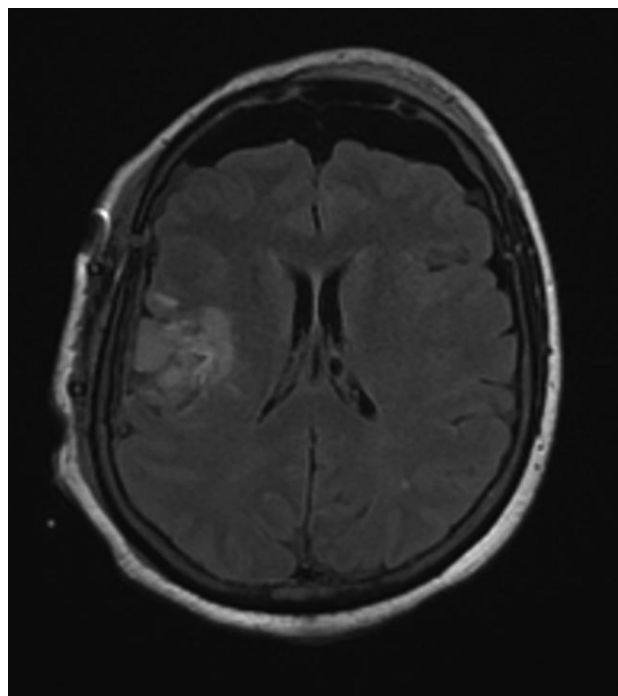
Case 2. Postoperative T2–fluid-attenuated inversion recovery magnetic resonance imaging sequence (axial view) showing the area of tumor resection and effects of surgical manipulation on white matter.
